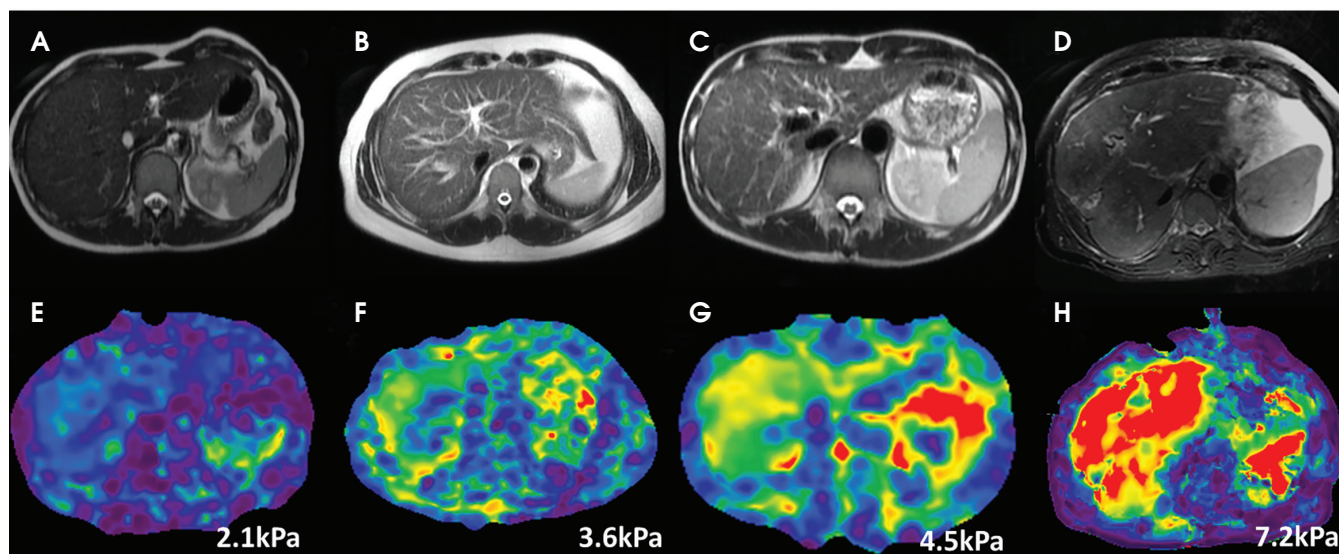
Axial T2-weighted MRI images of normal healthy volunteer (A), stage 2 fibrosis (B), stage 3 fibrosis (C), and stage 4 fibrosis (D). Corresponding MRE stiffness maps (E-H). Numbers in right lower corners are mean stiffness of liver parenchyma.
